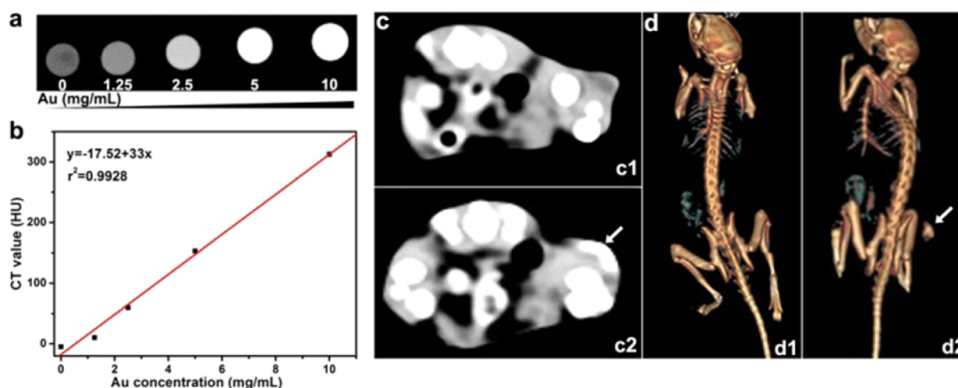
(a) CT images and (b) CT value (HU) of Au–Cu₉S₅ NPs dispersion as a function of the particle concentrations. Cross-sectional CT images of tumor before (c1) and after injection of Au–Cu₉S₅ NPs (c2), and their corresponding 3D reconstructed CT images before (d1) and after injection (d2) of Au–Cu₉S₅ NPs. The arrow heads point to the tumor sites.
